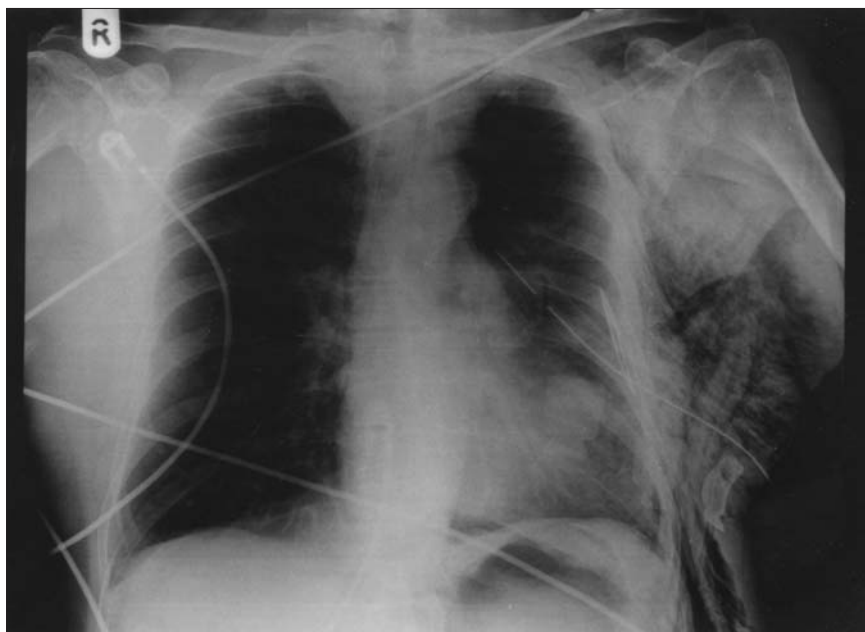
Chest radiograph showing intrapleural scalpel blade within left hemi-thorax and subcutaneous emphysema.
